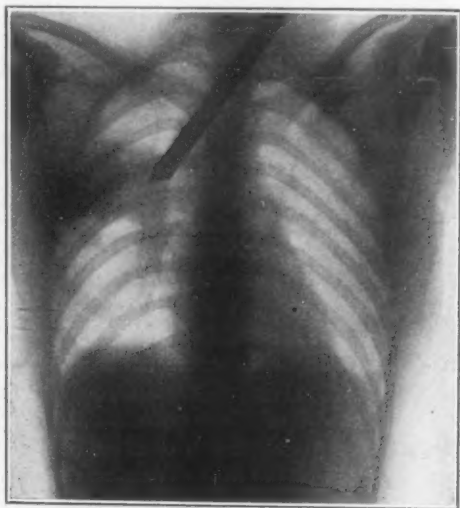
Radiograph (by Dr. George C. Johnston) of bronchoscope in the right upper lobe bronchus of a woman of 25 years (patient of Dr. Otto C. Gaub). The bronchoscope was inserted through the mouth and the angle is shown to be as advantageous as would be possible through a tracheotomic wound. The position of the patient is easy and natural in this instance, the radiograph being made for verification of the overlay localization in a suspected case of interlobar abscess. Had demonstration been the object, the upper part of the tube could easily have been brought to the clavicle.
